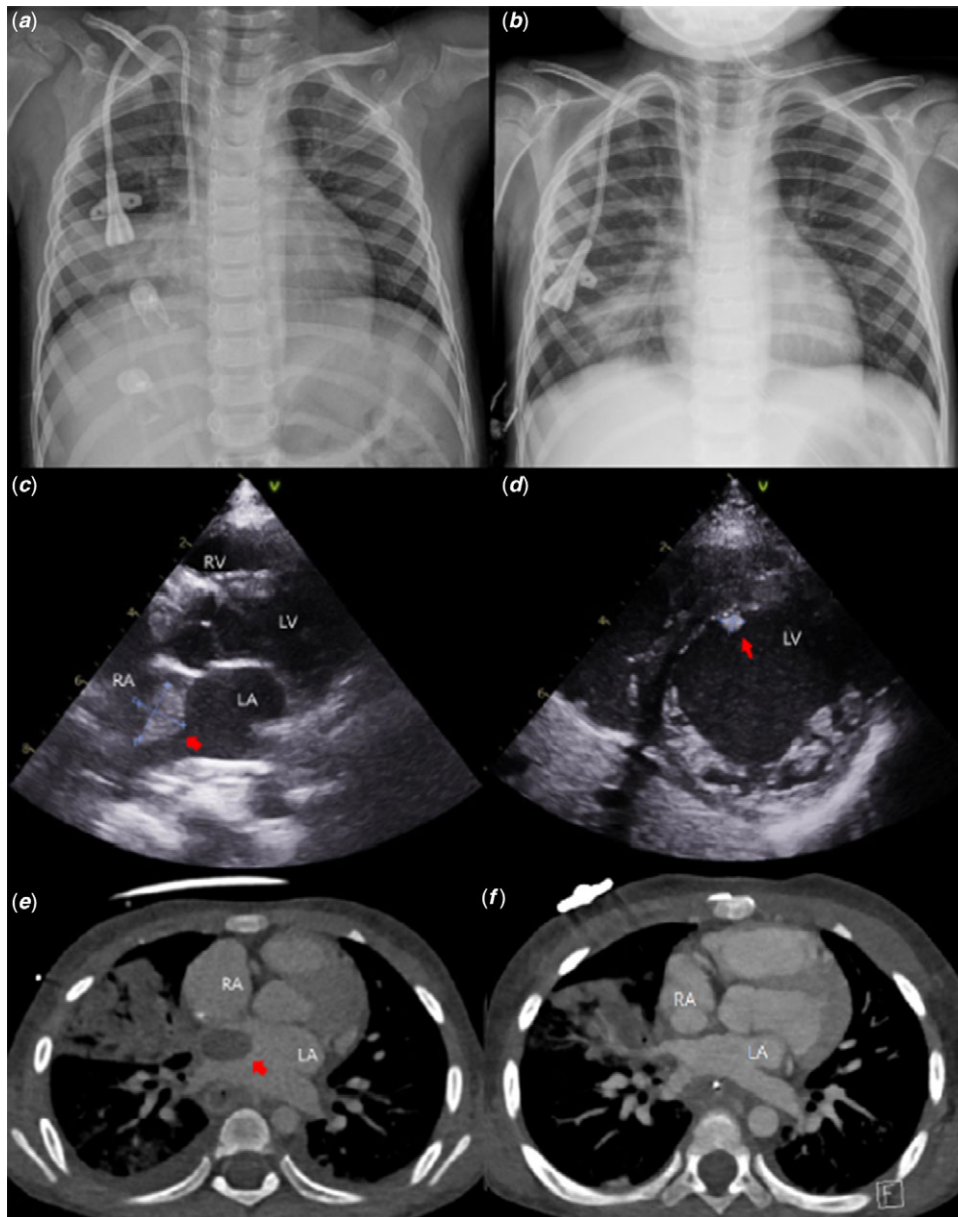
Imaging studies of case 2. (a) On the day of admission, right middle and lower lobar consolidations were shown. (b) On the 12 days after thrombectomy, right middle lobar consolidation improved. (c) Echocardiography showed a large thrombus (14.4 × 11.4 mm) in the left atrium and (d) another small thrombus (4.4 × 3.2 mm) in the left ventricular apex. (e) Cardiac CT revealed a 2.5-cm sized filling defect at the left atrium, obstructing the right middle pulmonary vein associated with lobar airspace consolidation of the right middle lobe. (f) After surgical thrombectomy, there was no residual intracardiac thrombus, but there was residual lobar airspace consolidation of the right lower lobe on cardiac CT.
